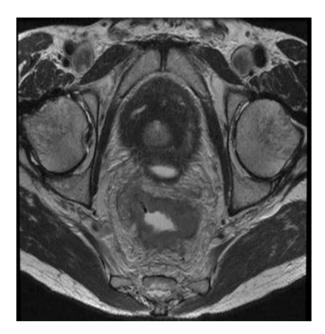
MRI of pelvis showing rectal cancer invasion into mesorectum with intact CRM
